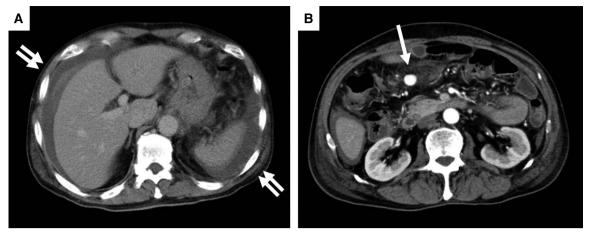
(A) Massive hemoperitoneum was observed on abdominal plain CT (double arrow). (B) Enhanced lesion continuous to blood vessel was observed on contrast-enhanced abdominal CT (arrow). CT: computed tomography
